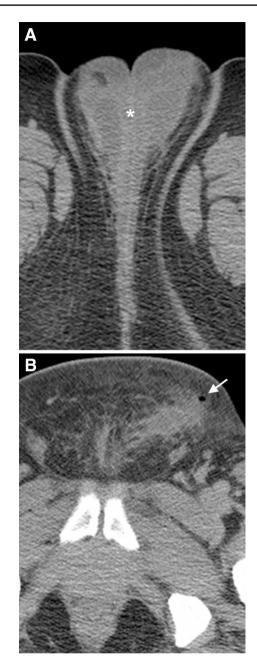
Fournier gangrene after gender reassignment surgery. a, b Axial enhanced CT images in a patient after gender reassignment surgery show a large abscess at bilateral labia majora (*) with soft tissue gas (arrow)
